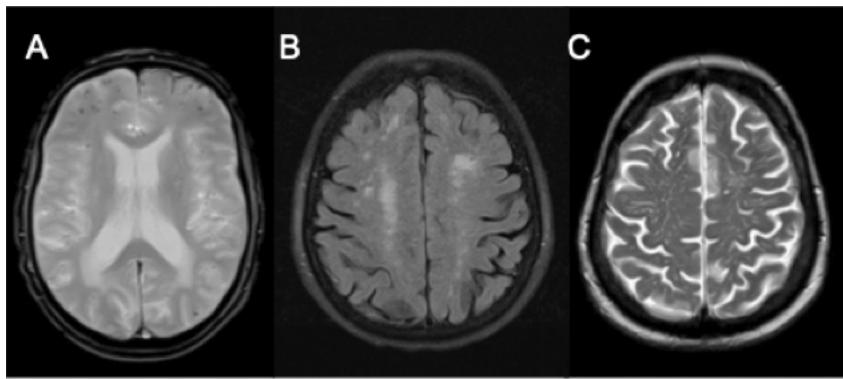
Brain MRI pathological features of cerebral amyloid angiopathy pathology. (A) Axial T2* image from a 76-year-old male patient showing left frontal cortical siderosis and multiple foci of microhemorrhages of predominant frontal location bilaterally. (B) Axial T2-FLAIR image from a 73-year-old female patient showing centrum semiovale white matter T2 hyperintense lesions attributed to chronic small vessel ischemia. (C) Axial T2 image from a 78-year-old female patient showing enlarged perivascular spaces in the centrum semiovale. (Adapted from Pinho et al, AJNR, 2023 [94])
